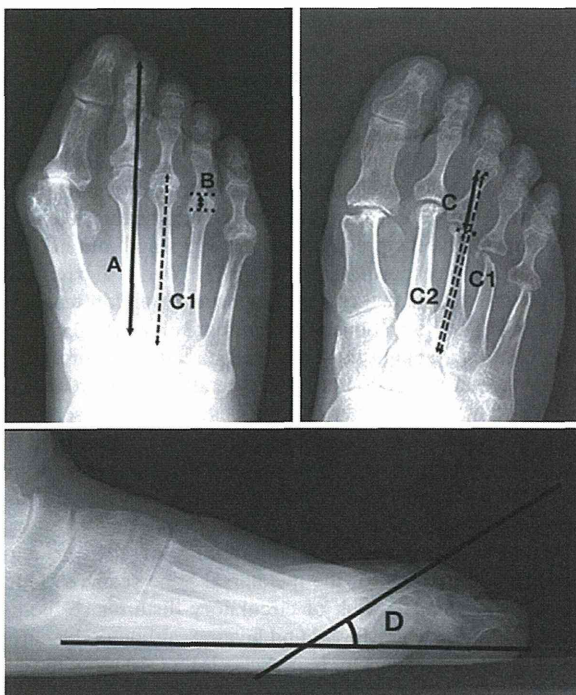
Pre- and postoperative radiological evaluation: a) Preoperative dorsoplantar weight-bearing radiograph. A; forefoot length, B; overlap length of the dislocated MTP joint, C1; preoperative length of the metatarsal bone. b) Postoperative dorsoplantar weight-bearing radiograph. C2; postoperative length of the metatarsal bone. C = C1–C2. c) Preoperative lateral weight-bearing radiograph. D; MTP dorsal flexion angle.
